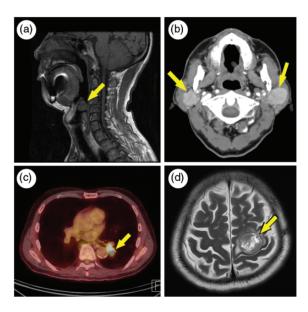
Imaging studies of the patient over time. (a) In December 2007, a 1.8-cm polypoid mass was observed in the epiglottis on magnetic resonance imaging (MRI) T2 weighted image. (b) In July 2015, neck contrast computed tomography (CT) revealed several enhancing masses, up to 2.4 cm, in both parotid glands. (c) In August 2015, a hypermetabolic endobronchial tumor with maximum standardized uptake value (SUVmax) of 10.3 was identified in the superior segmental bronchus of the left lower lobe on positron emission tomography (PET)-CT. (D) In November 2015, brain MRI revealed a 3.1-cm enhancing mass in the left frontal lobe on T2 weighted image.
